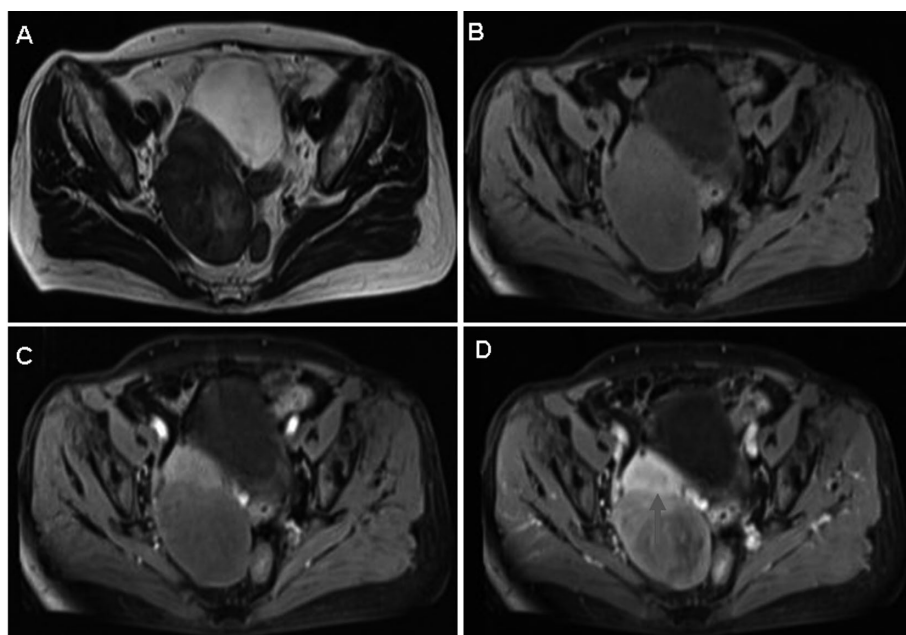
A 50-year-old woman with fibroma which was misdiagnosed as uterus subserous myoma. (A) Axial T2-weighted imaging shows high heterogeneous signal. (B) Axial fat-suppressed T1-weighted imaging shows low heterogeneous signal. (C) Axial enhanced T1-weighted imaging shows slight enhancement on the wall of mass in the artery phase. (D) Axial enhanced T1-weighted imaging shows high enhancement on the wall of mass in the vein phase. The lesion was adjacent to the posterior wall of uterine and the edge was rough (red arrow), which was misdiagnosed as uterus subserous myoma.
